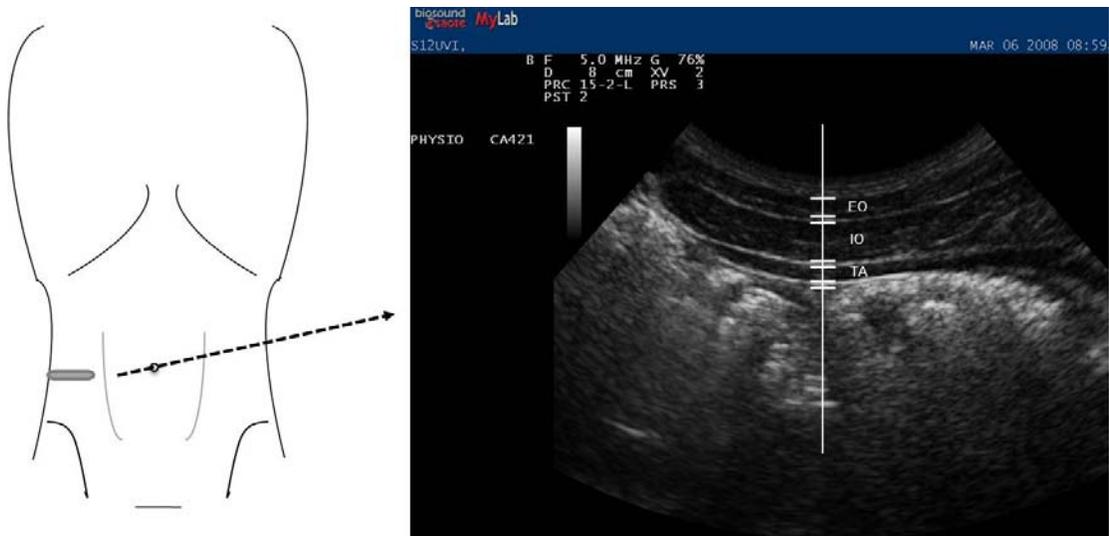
A. Lateral abdominal wall (LAW) imaging site. B. Transverse ultrasound image of the right lateral abdominal wall showing a vertical reference line in the middle of the image along which measurements of transversus abdominis (TA), internal oblique (IO), external oblique (EO) muscles, and intervening connective tissue plane thicknesses were made.
